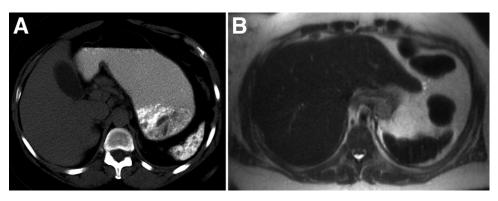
A 47-year-old woman with SCD and history of autosplenectomy. Unenhanced CT of the abdomen (*A*) shows increased density of the small spleen. On MRI (*B*) the spleen is also small and diffusely hypointense on all sequences, consistent with findings of dense calcification on CT. The calcifications and small size make detection of the spleen difficult on ultrasound.
